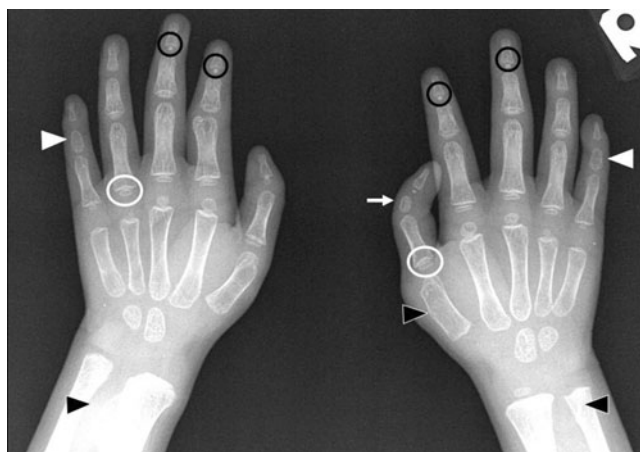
Hand radiograph taken at the age of four, after excision of bilateral duplicated thumbs. The right thumb is triphalangeal with extra phalange between the proximal and distal phalanges (*white arrow*). There is mild clinodactyly at both thumbs. Cone-shaped epiphyses are present at the proximal phalanges of right thumb and left ring finger (*white circles*). Ivory epiphyses are evident in all distal phalanges with epiphyses ossified (*black circles*). Bilateral 5th middle phalanges are hypoplastic (*white arrowheads*). There are small exostoses at right 1st metacarpal, right distal ulna, and left distal radius (*black arrowheads*)
